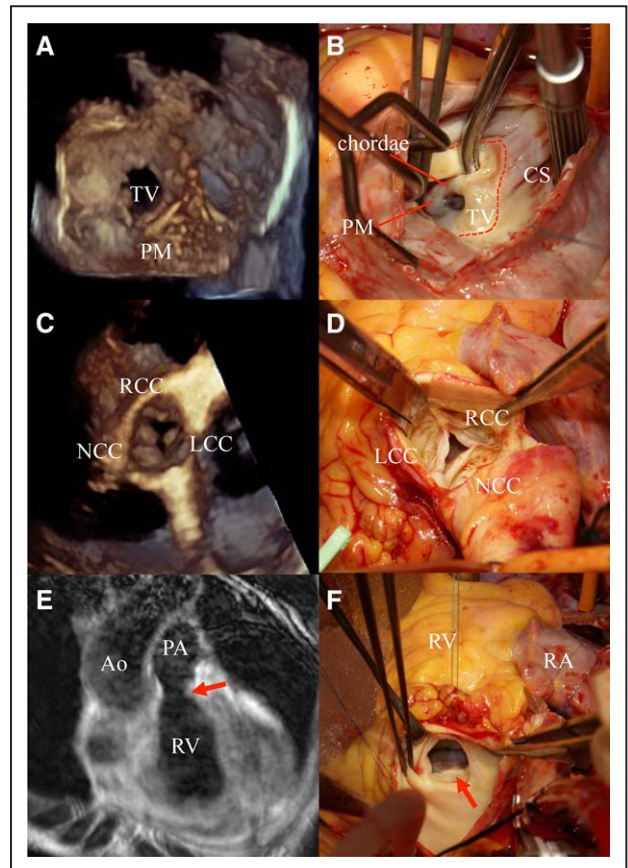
The 3-dimensional echocardiograms, cardiac magnetic resonance image (MRI), and intraoperative view of the heart valves. A and B, Three-dimensional echocardiogram (A) and intraoperative view (B) of the tricuspid valve with thickening of the chordae and papillary muscle. Red dotted line indicates tricuspid annulus. C and D, Three-dimensional echocardiogram (C) and intraoperative view (D) of the aortic valve. E and F, Cardiac MRI (E) and intraoperative view (F) of the pulmonary valve (arrow). Ao indicates aorta; CS, coronary sinus; LCC, left coronary cusp; NCC, noncoronary cusp; PA, pulmonary artery; PM, papillary muscle; RA, right atrium; RCC, right coronary cusp; RV, right ventricle; and TV, tricuspid valve.
